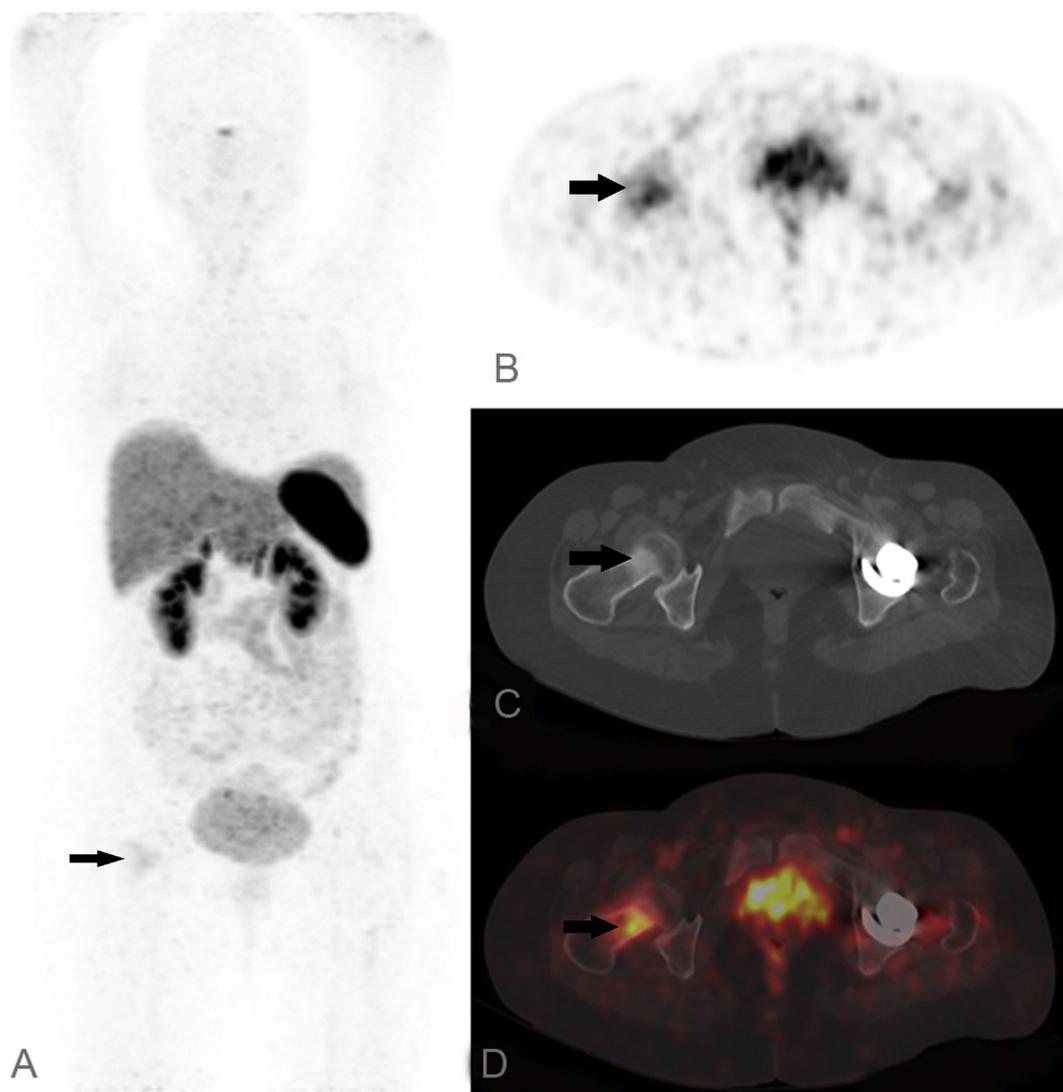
44-Year-old female with generalized muscle aches. FGF 23 was elevated (339 RIU/ml). Ga-68 DOTATATE images (A) Maximum intensity projection images and (B) axial PET images, show abnormal focal tracer uptake in the region of right femoral neck, SUV 8.0. Physiological tracer uptake is seen in the pituitary, liver and spleen with excretion of tracer through the kidneys. (C) Transaxial CT and (D) fused PET/CT localize the increased tracer uptake to a sclerotic lesion in the right femoral neck, which was later pathologically consistent with phosphaturic mesenchymal tumor.
